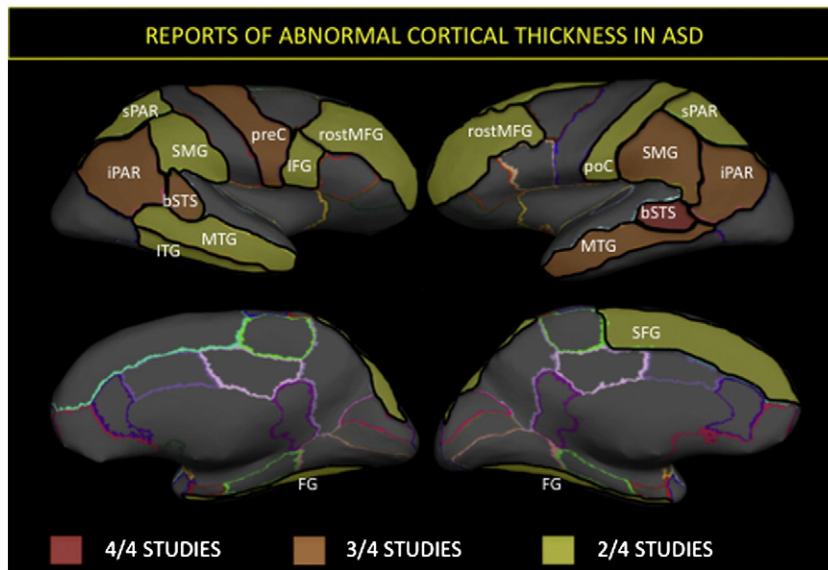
Synthesis of findings from existing studies of cortical thickness differences between individuals with ASD and TDCs. Four (Hadjikhani et al., 2006; Raznahan et al., 2010b; Scheel et al., 2011; Wallace et al., 2010) of the six (Chung et al., 2005; Mak-Fan et al., 2012) existing studies that compare cortical thickness (CT) between people with an ASD diagnosis and controls have used the same procedure for surface based cortical morphometry (Fischl and Dale, 2000), which allows the findings of these studies to be integrated using the same nomenclature for cortical parcellation into gyral-based regions of interest (Desikan et al., 2006). The number of times each gyral region has shown an abnormality in ASD compared to controls across these four studies is color coded for those regions that have shown abnormalities in at least two studies. Despite methodological differences between studies, there are clear convergences in reported patterns of CT abnormality (collapsing across reports of CT excess, deficit and age-related abnormalities). [SFG—superior frontal gyrus, rostrMFG—rostral middle frontal gyrus, IFG—inferior frontal gyrus, preC—precentral gyrus, postC—postcentral gyrus, spar—superior parietal lobule, iPL—inferior parietal lobule, bSTS—bank of the superior temporal sulcus, MTG—middle temporal gyrus, ITG—inferior temporal gyrus, FG—fusiform gyrus].
